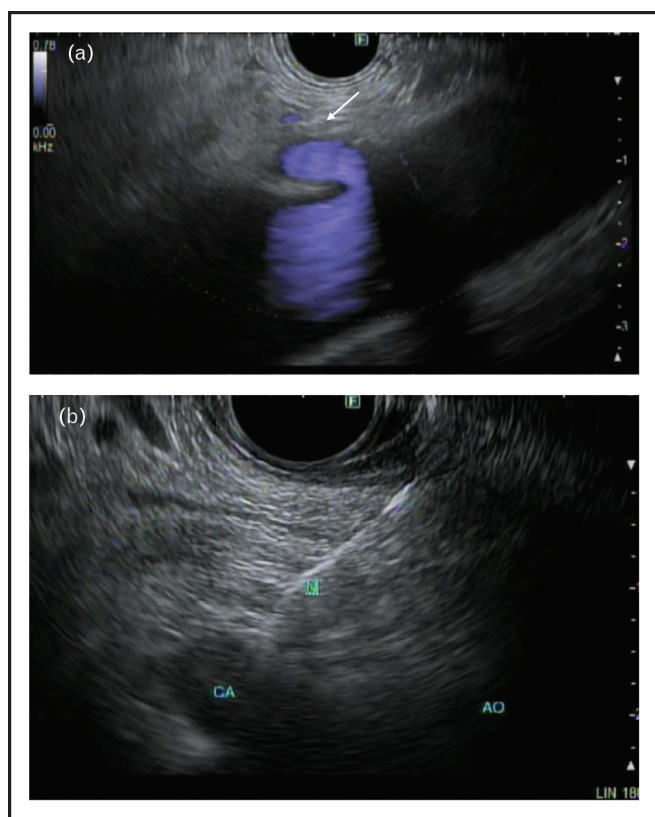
(a) Linear endoscopic ultrasound image showing blood flow of the aorta and celiac artery take off. The area above the take off (arrow) is the celiac axis. (b) Linear endoscopic ultrasound (EUS) image of a 22-gauge needle inserted into the celiac axis during a celiac plexus block.
